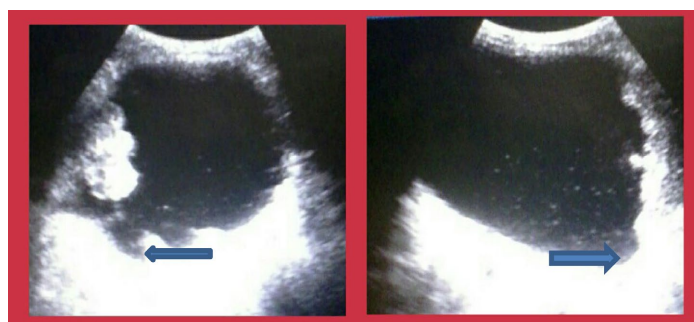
Ultrasound pictures of bladder masses and irregularity of the bladder walls in an infected subject.
